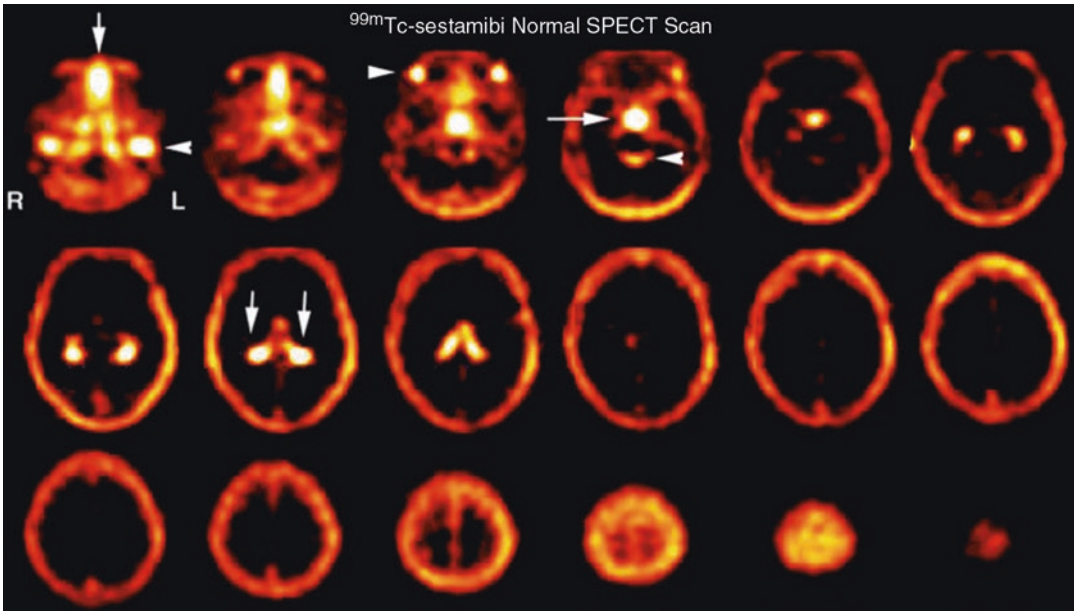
Normal ^{99m}Tc -MIBI brain SPECT scan. The figure shows very low uptake of MIBI in the normal brain. However, similar to the thallium brain SPECT scan, there are several structures just inferior to the cranium which can interfere with accuracy of tumor recurrence identification. As seen in the normal ^{201}Tl brain SPECT scan, there is intense uptake in the jugular veins (row one, image one, arrow) and the nasopharynx (row one, image one, arrow). There is also intense uptake in the salivary glands (row
